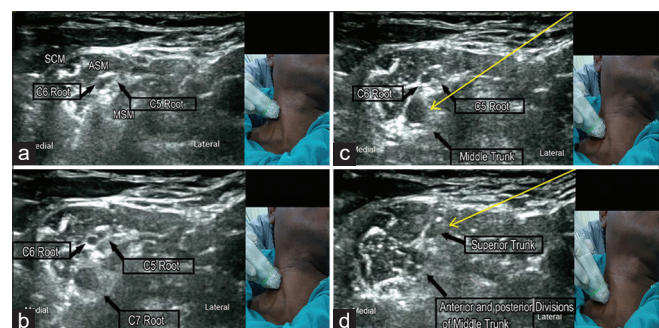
Sonoanatomy of the right side brachial plexus and the position of the ultrasound transducer in the neck are demonstrated. (a) Cervical root (C) 5, C6. SCM: Sternocleidomastoid, ASM: Anterior Scalene Muscle, MSM: Middle Scalene Muscle. (b) Emerging of C7 root (c) C5-C6 about to unite to form superior trunk. C7 continues as middle trunk. (d) Superior trunk formed, middle trunk divided into the anterior and posterior divisions. The yellow arrow indicates the trajectory the needle is passed in in-plane technique to block the middle trunk (C) and Superior trunk (D). The black arrow indicates parts of the brachial plexus
